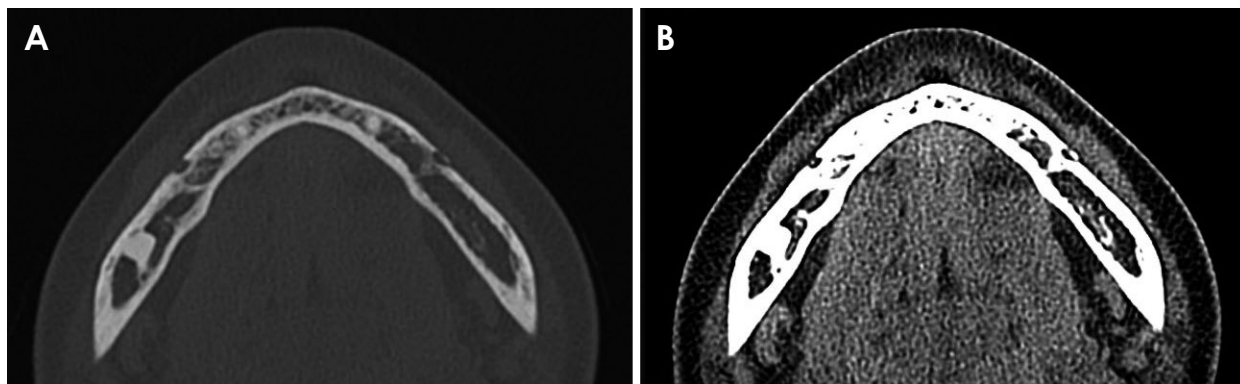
A. An axial multislice computed tomography (MSCT) image under the bone window setting, captured 6 months following the initiation of endodontic treatment, demonstrates recovery of the periapical lesion. B. MSCT image with the soft tissue window setting, taken concurrently with image A. This image reveals the normal appearance of the facial muscle and the restoration of the fat plane in the buccal aspect of the right mental foramen.
